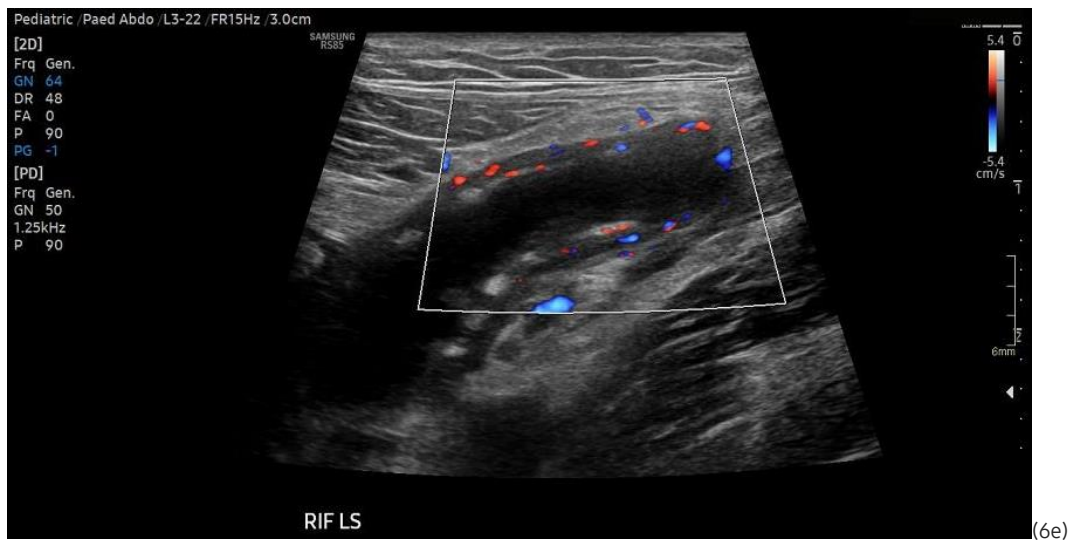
The ultrasound image depicts the right iliac fossa (RIF) in a teenager patient, using color Doppler imaging. The longitudinal view (LS) captures a tubular structure, which appears dilated and surrounded by echogenic fat, indicating inflammation. The color Doppler shows increased blood flow in the wall, consistent with hyperemia, a common finding in active inflammation. The structure's non-compressibility further points towards appendiceal pathology, as normal bowel loops tend to collapse under pressure. The surrounding tissue exhibits increased echogenicity, consistent with peri-appendiceal fat stranding. This is secondary to surrounding inflammation, reinforcing the suspicion of acute appendicitis.
